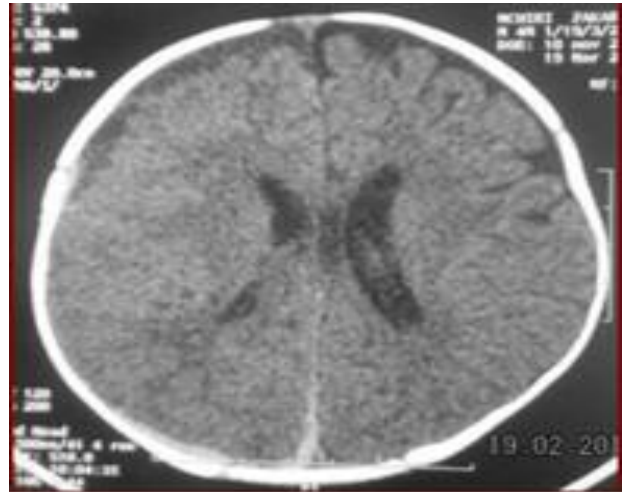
Cranial computed tomography showing disappearance of the cerebral hematoma from the parenchymal tissue
